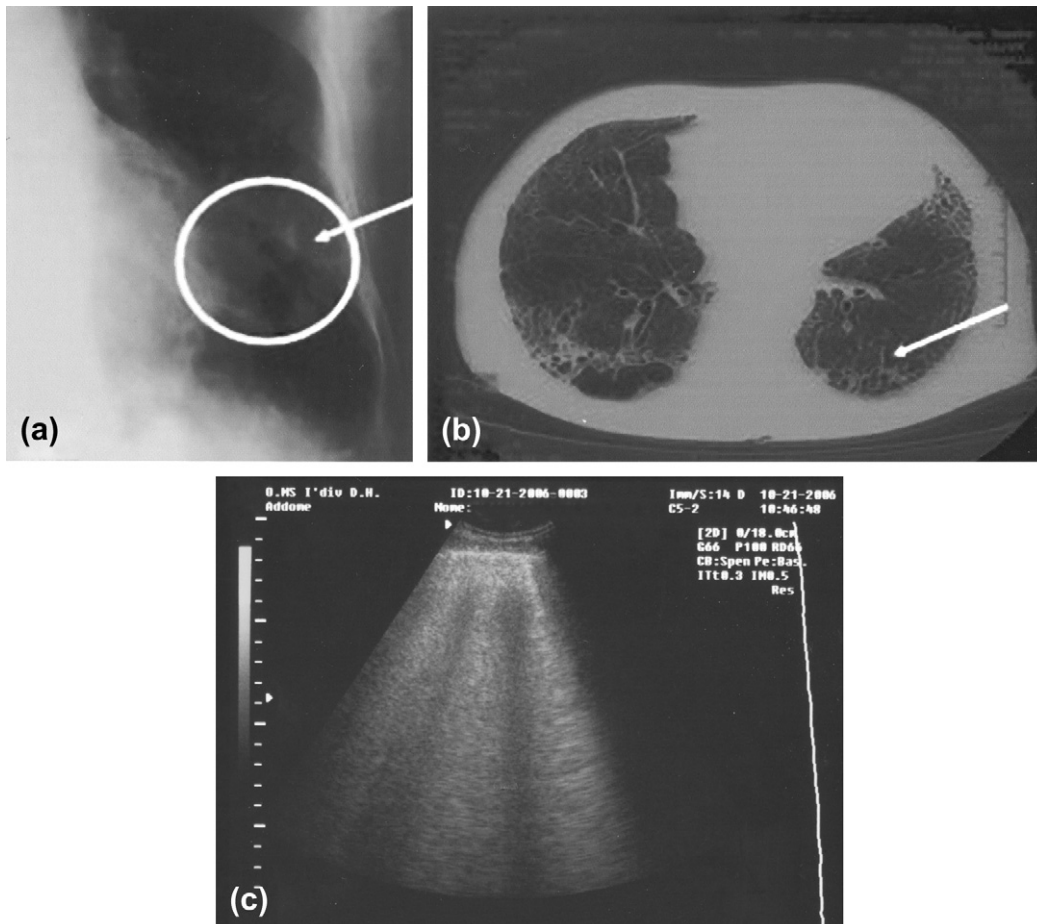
(a–c) Plain film, computed tomography, and ultrasound: interstitial pattern in interstitial pneumonia.
